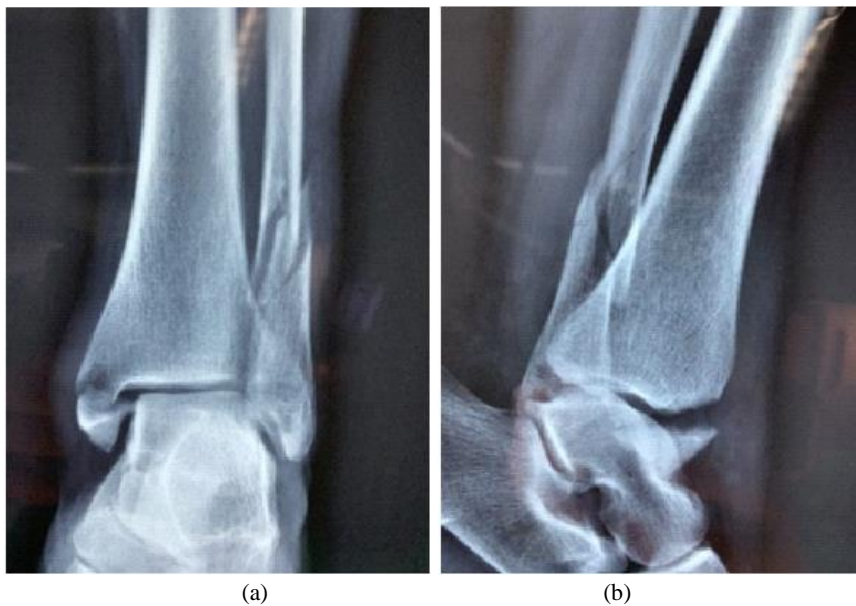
Preoperative x-rays (anteroposterior (a) and lateral (b) views) appear a bimalleolar fracture Weber C
